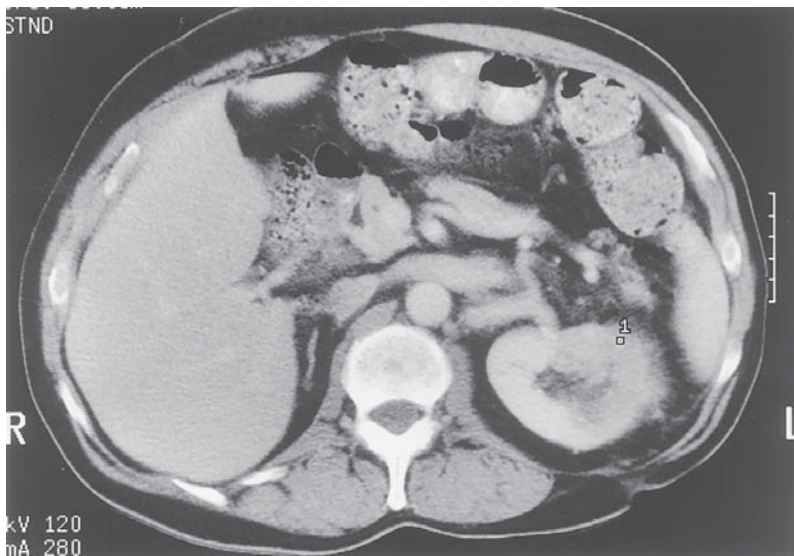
CT scan of an infiltrating lesion in the left kidney. Biopsy confirmed the presence of high-grade transitional cell carcinoma invading the parenchyma.
